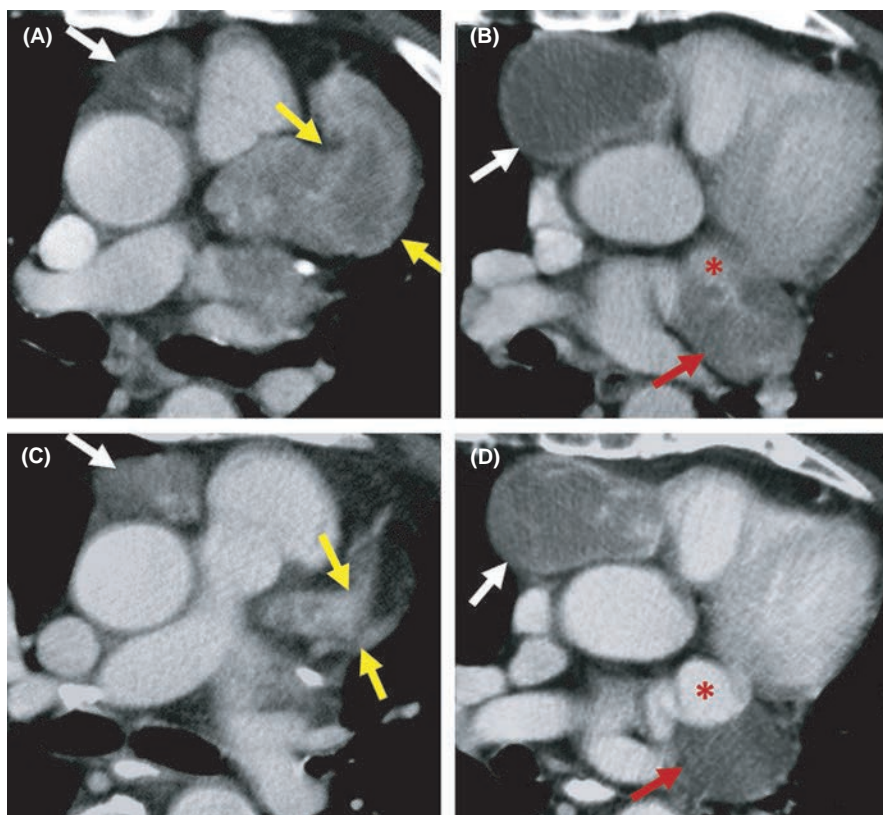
Axial post-contrast computed tomography (CT) images show a soft tissue appearance surrounding the left anterior descending artery (LAD) with heterogeneous contrast enhancement (A, yellow arrows). Also, there are aneurysms with luminal thrombus in the right carotid artery (RCA) (A-B, white arrow) and circumflex (Cx) artery (B, red arrow). Cx aneurysm is partially thrombosed with the patent lumen shown as a red asterisk (B). Follow-up axial CT images show that the soft tissue like wall thickening in LAD significantly regressed (C, yellow arrows). RCA (C-D, white arrow) and Cx (D, red arrow) aneurysms are stable in size, but the patent lumen of Cx aneurysm increased in the interval period (D, red asterisk)
